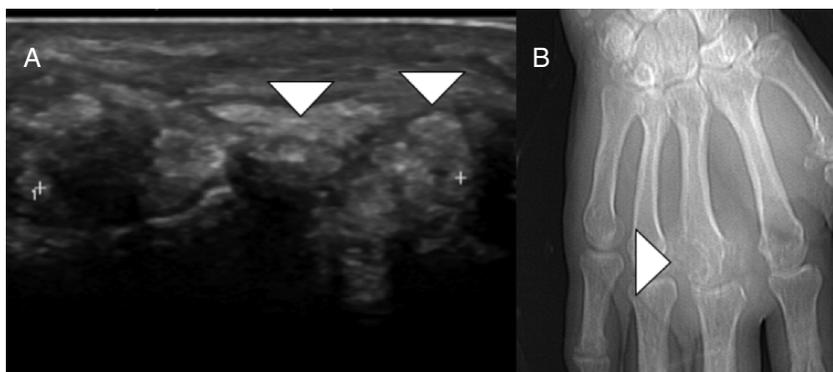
(A) A soft tissue tumor is observed in the dorsal region at the base of the third finger, which is of diffuse echotexture (white arrow heads). (B) Image of CT locator: a lesion is observed which destroys the cortical of the head of the third metacarpal (white arrow head).
